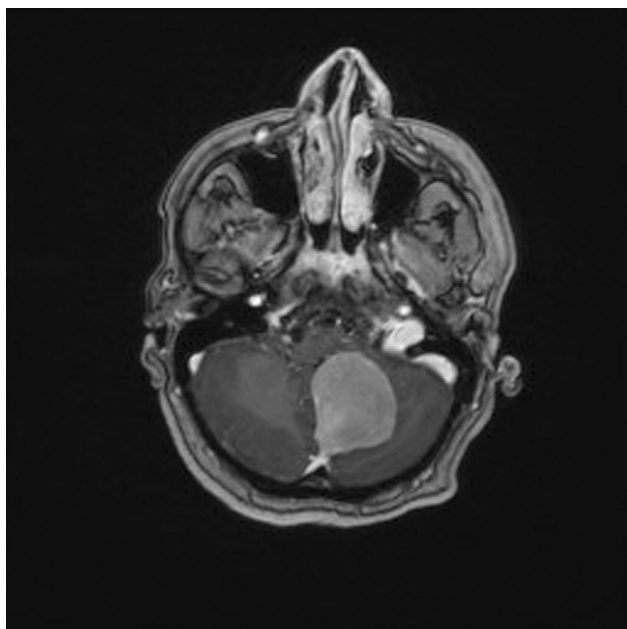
T1 axial-weighted magnetic resonance imaging with contrast demonstrating a left foramen magnum meningioma.
